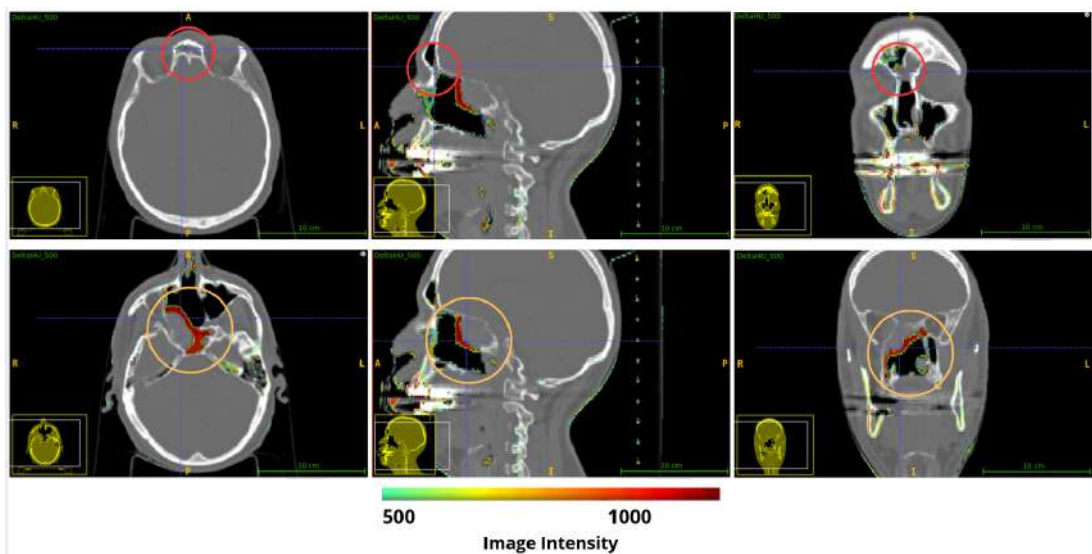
Thresholded  $\Delta\text{HU}$  maps ( $\Delta\text{HU} > 500$ ) superimposed on CT images, emphasizing the morphological variations identified in Fig. 3.4.
